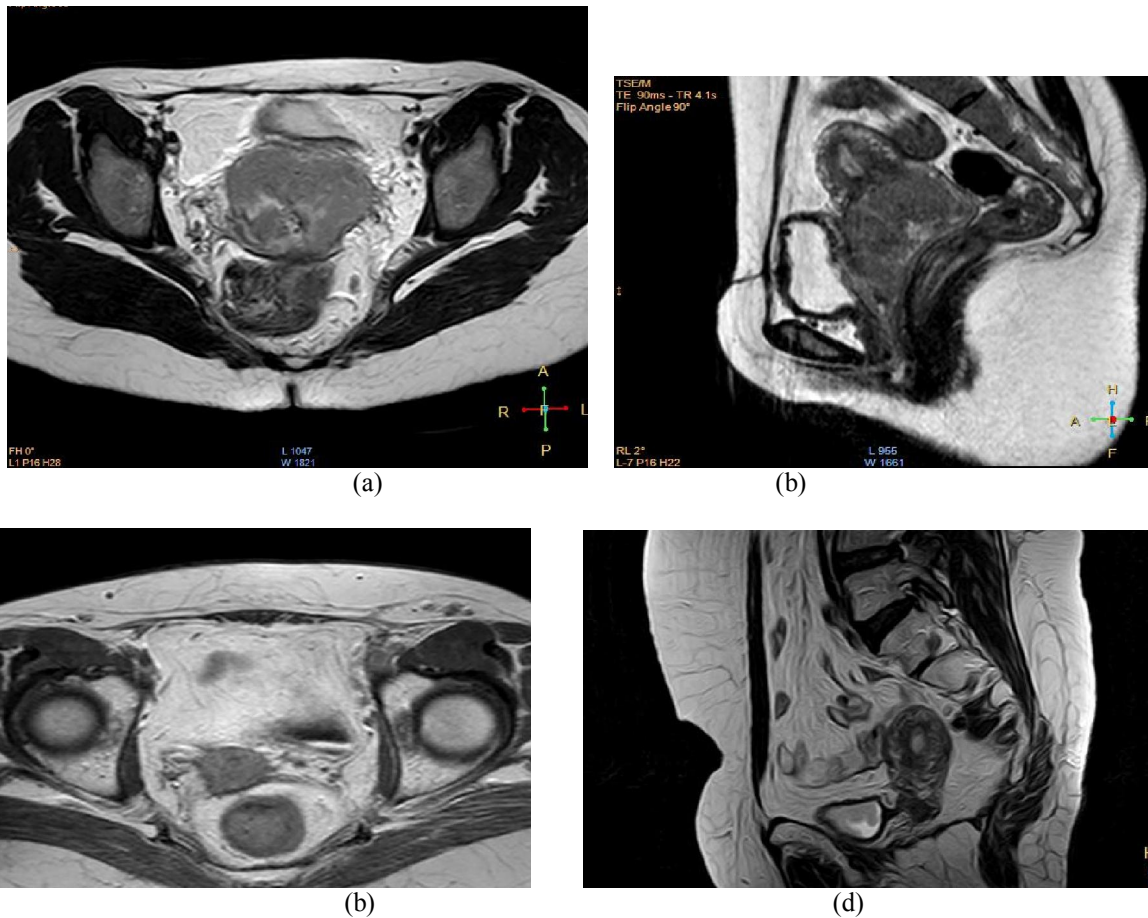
MRI of 42 years old female patient with cancer cervix. (a) T2W MRI coronal and (b) T2W sagittal images of the pelvis pre-chemoradiation, show cervical carcinoma with localized pelvic infiltration, but no lymph nodes enlargement. While, (c) Axial T2W, and (d) Sagittal T2W images post-chemoradiation, show significant decrease in the size of the cervical mass with RD >1cm.
